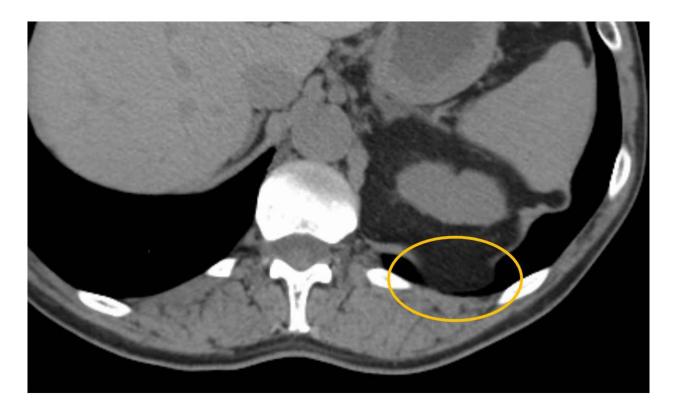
Bochdalek hernia. CT scan shows a posterior diaphragmatic defect and fat herniation without organ entrapment.
